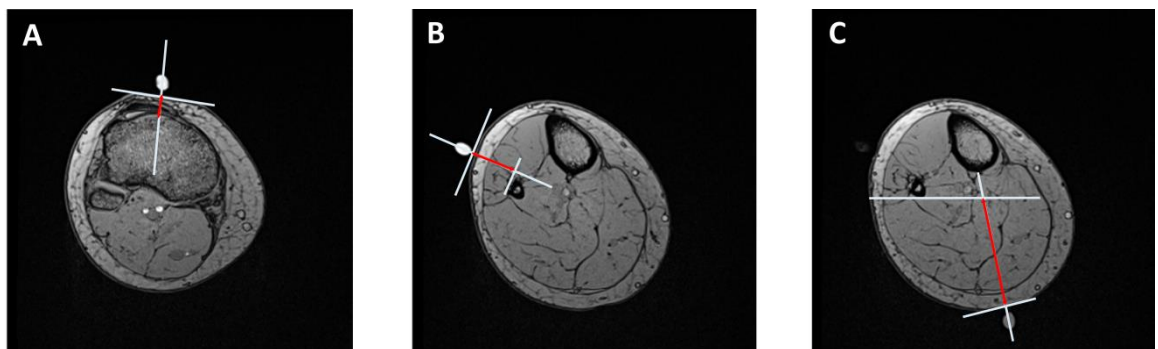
Transverse MRI slices of a participant's calf at baseline displaying how measurements of gross tissue deformation under the indenter sites were made at the A) patellar tendon, B) lateral calf and C) posterior calf, Note: white represents construction lines and red represents measurement taken
